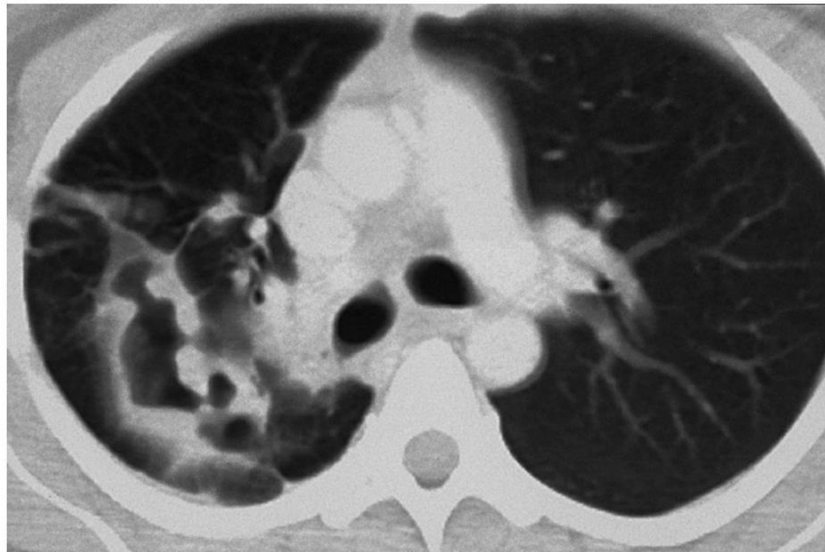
Pulmonary spread of recurrent respiratory papillomatosis. Note lytic, cavitary lesions on computed tomography.
